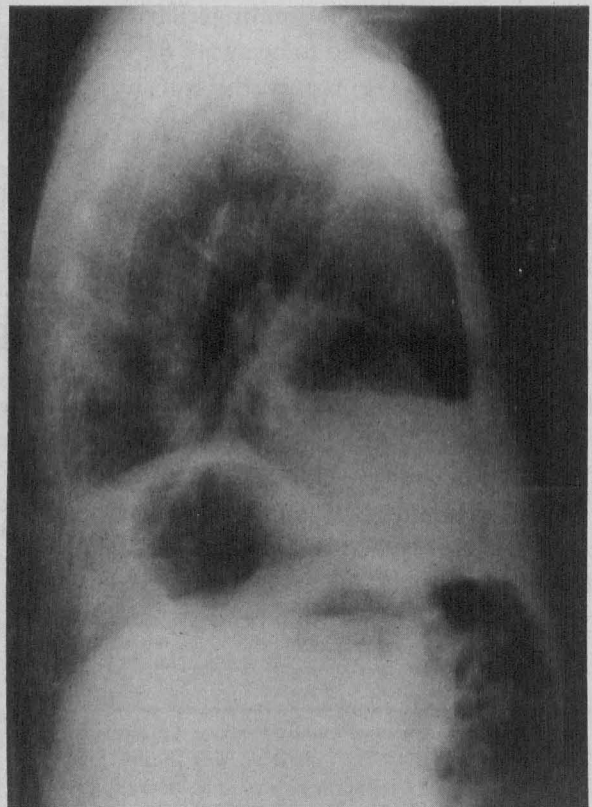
Admission radiograph – lateral view.
